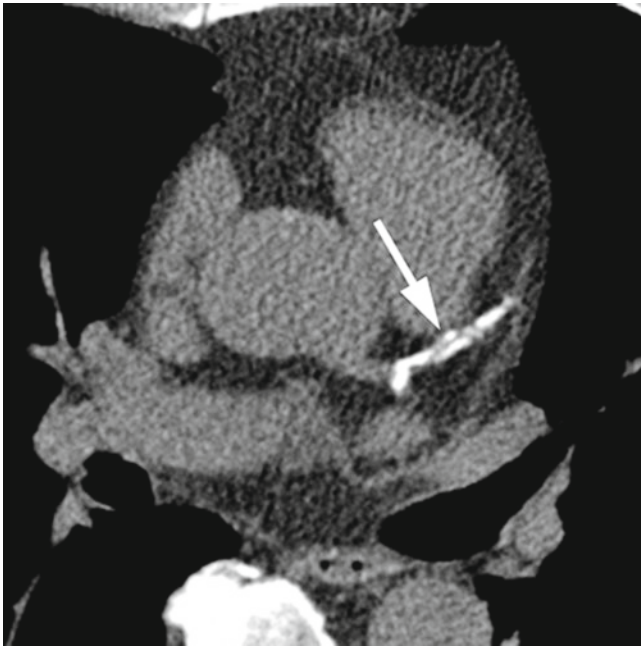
Detection of coronary calcium by EBCT. The first clinical application of cardiac CT was the detection and quantification of coronary calcium for the purpose of risk stratification. Here, a cross-sectional EBCT image (3.0 mm slice thickness, 100 ms acquisition time) shows calcification of the left main bifurcation, proximal left circumflex, and proximal left anterior descending coronary artery (arrow)
